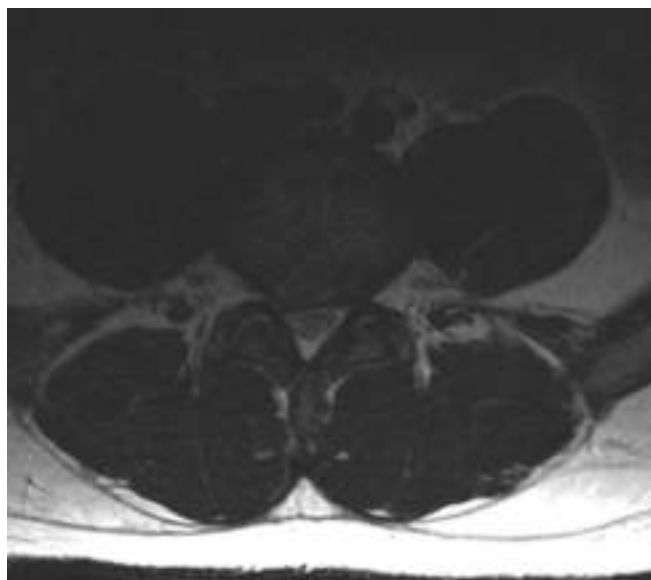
L4/5 right disc herniation postoperative MRI
